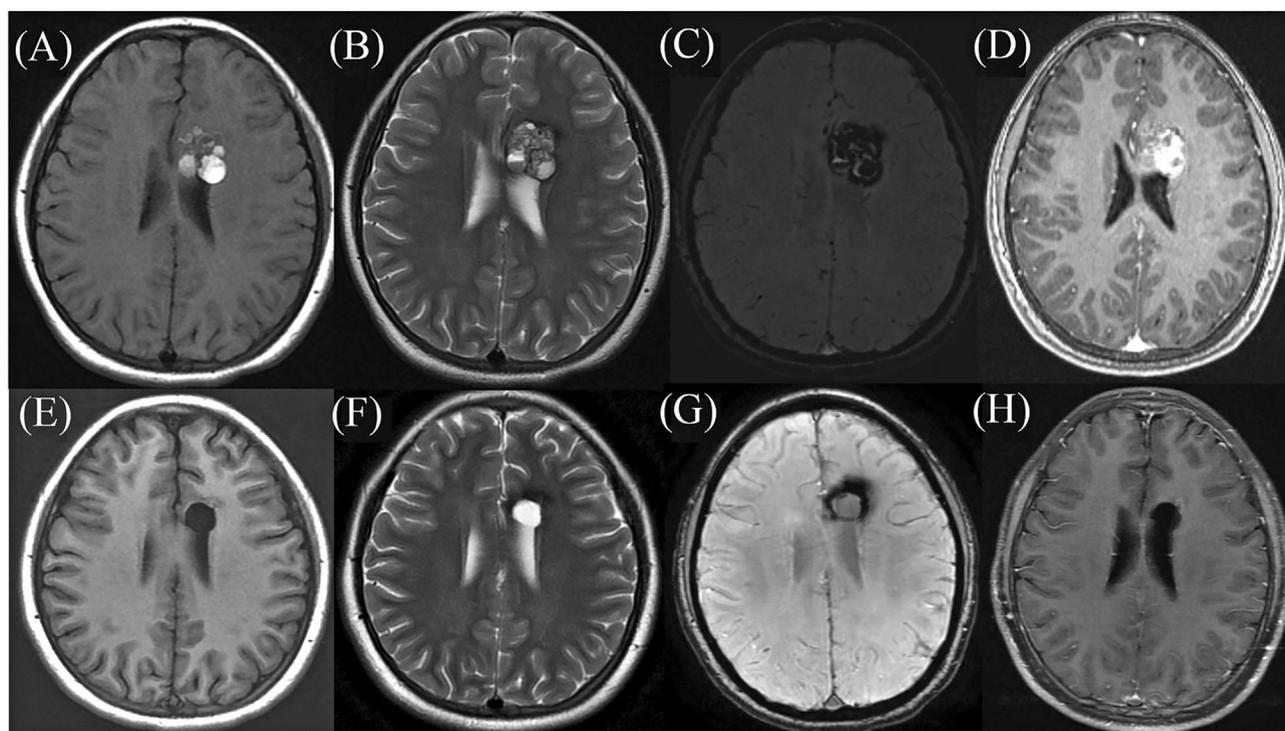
Preoperative and postoperative magnetic resonance imaging (MRI) of a cavernous malformation in a 17-year-old girl with a headache for 1 month. Preoperative MRI showed a 3.0 cm × 2.2 cm × 2.0 cm lesion in the left frontal lobe, adjacent to the ventricle, exhibited heterogeneous enhancement after gadolinium injection on axial view. The lesion was heterogeneously enhanced after gadolinium injection on axial view. (A) T1-weighted image; (B) T2-weighted image; (C) susceptibility-weighted image; and (D) Contrast enhancement axial image. Postoperative MRI showed that the lesion was totally resected (E–H), and the diagnosis was made as cavernous malformation pathologically.
